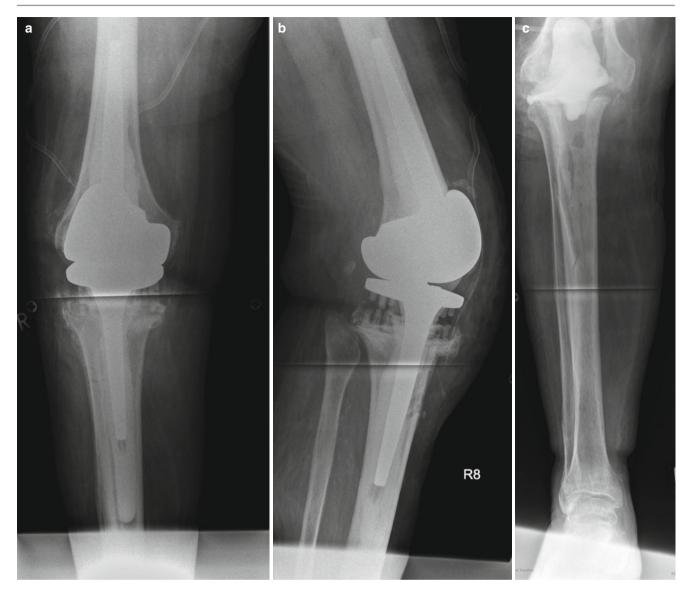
Seventy-three year-old man, total knee arthroplasty, early infection, unsuccessful preservation attempt. Comorbidity: Diabetes mellitus with polyneuropathy, nephropathy, hypertension, CVA 2005, COPD, allergic syndrome. (\mathbf{a} , \mathbf{b}) AP and lateral radiographs of the knee joint. (\mathbf{c} , \mathbf{d}) Explantation of the total knee endoprosthesis and insertion
